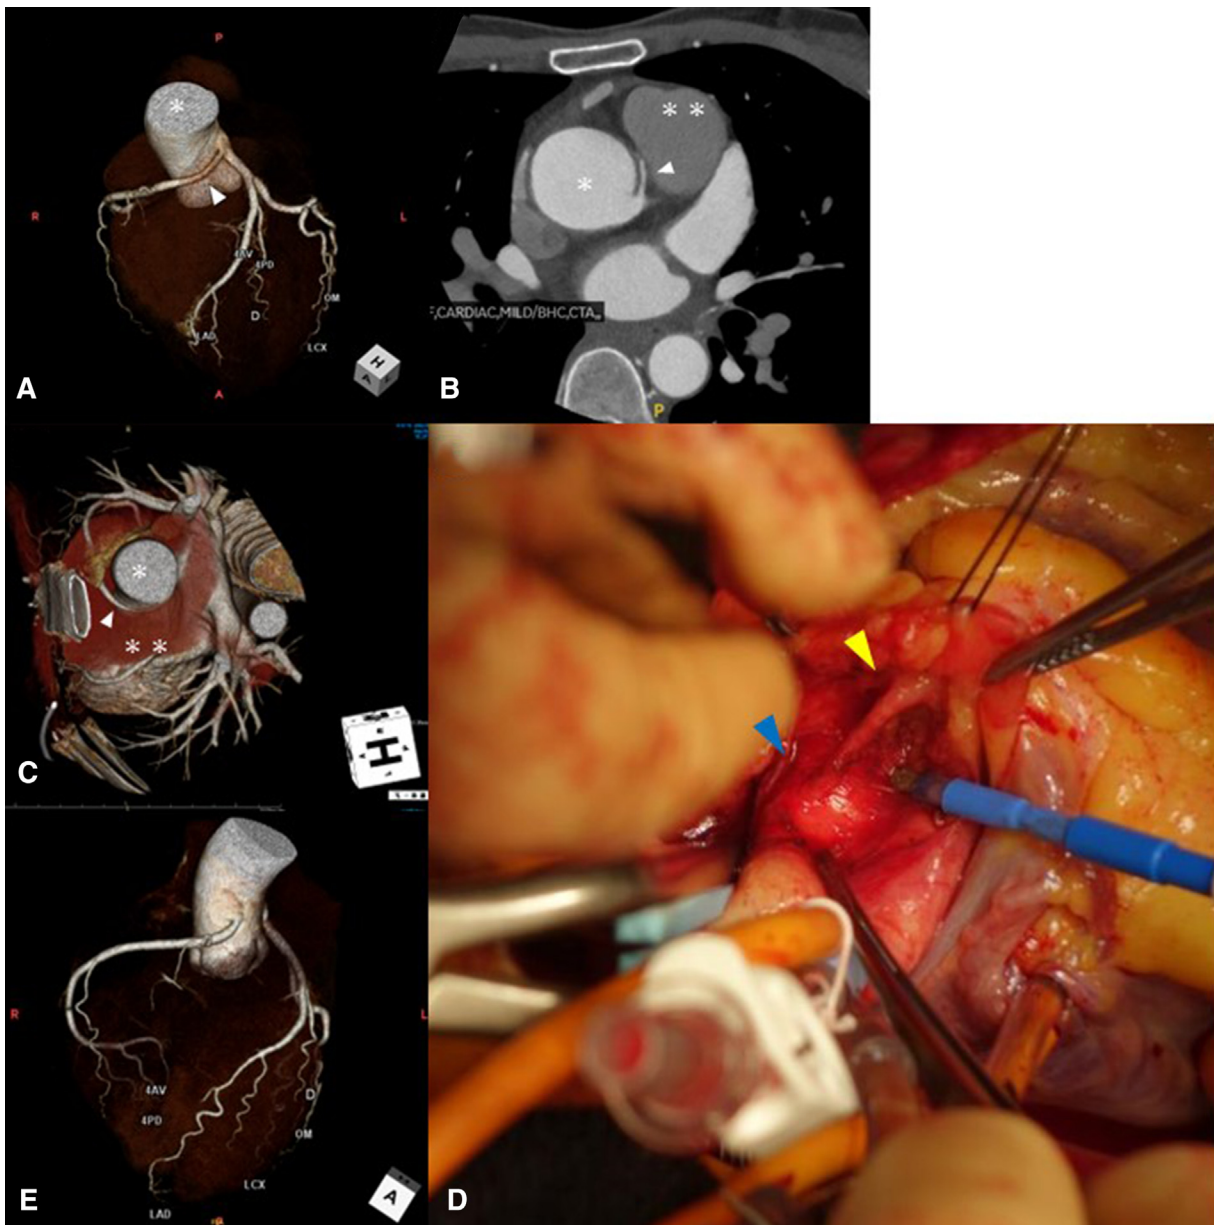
CCTA images and surgical view. A-C, Preoperative CCTA revealed luminal narrowing in the proximal lesion of the anomalous RCA arising from the LMCA (*arrowhead*). A and C, volume-rendered images; B, axial view, *ascending aorta, main pulmonary artery. D, Surgical view after dissection around the coronary sinuses showed that the right coronary artery firmly adhered to the aortic wall (*blue arrowhead*). The distal side of the right coronary artery was minimally dissected for anastomosis (*yellow arrowhead*). E, Postoperative image showing successful transposition of the RCA to the anterior aortic wall. The ligated anomalous RCA no longer contrasted immediately after LMCA bifurcation. CCTA, Coronary computed tomography angiography; RCA, right coronary artery; LMCA, left main coronary artery.
